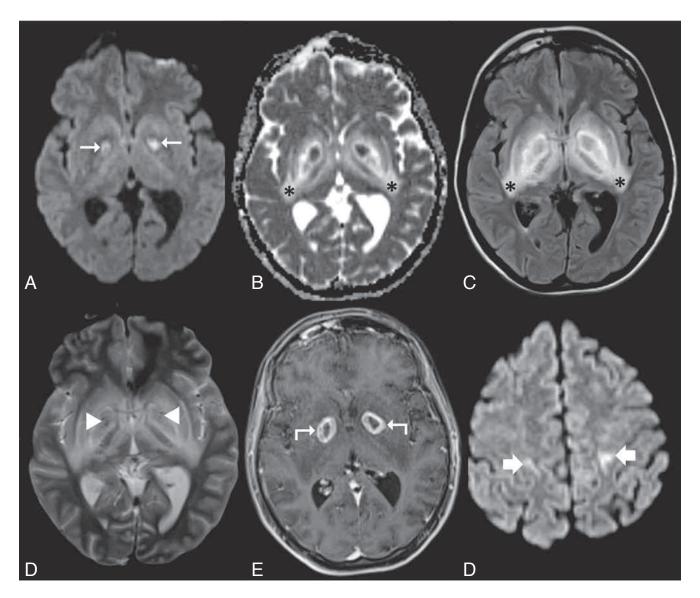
Brain MRI (pre and post gadolinium injection) performed 17 days after onset of symptoms: Acute bipallidal infarction (arrow) showing a hyperintense on DWI imaging (A) and hypointense on ADC sequences (B). Surrounded by vasogenic edema (asterisk) hyperintense ADC imaging (B) and FLAIR sequences (C).
